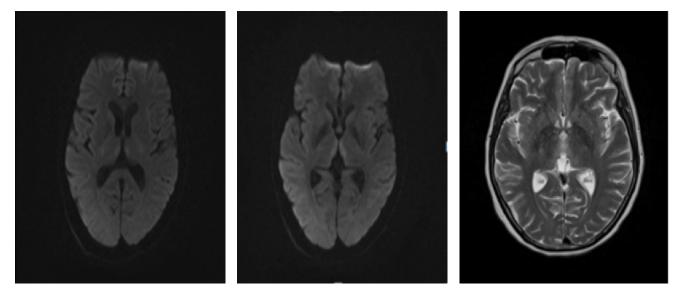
Brain MRI and diffusion MRI showed symmetric mild hyperintensities on T2-weighted sequences in bilateral medial thalamus.
